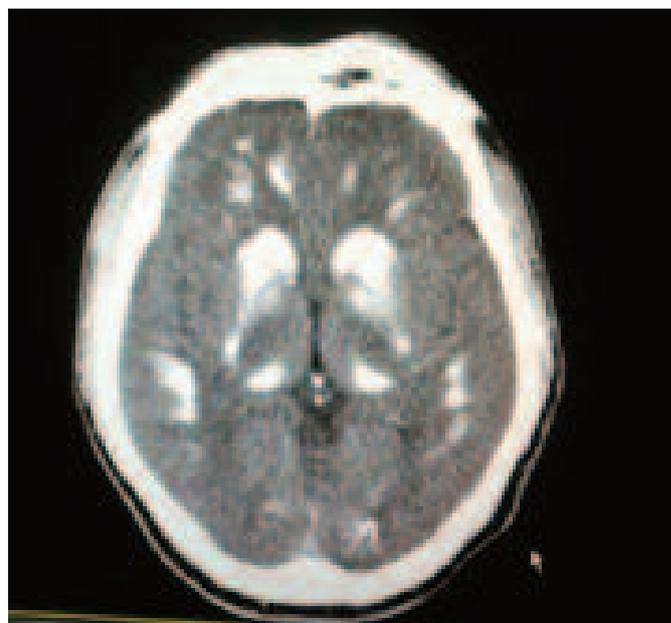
CT scans of patient 2, showing hyperdense patchy calcifications at the posterior fossa level, the dentate nucleus of both cerebellar hemispheres, the basal ganglia, the thalamus, and at the levels of the frontal parietal and occipital lobes of the deep subcortical area extending to the white matter.
